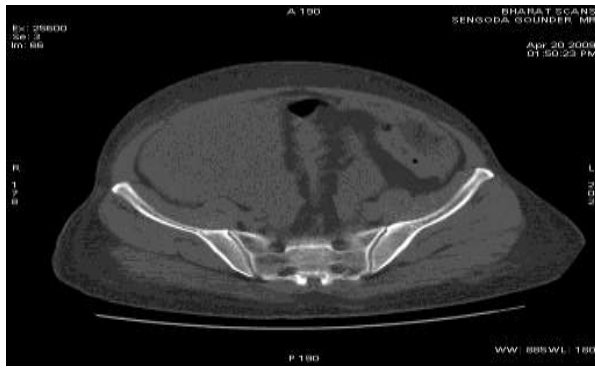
Normal SIJ by CT
